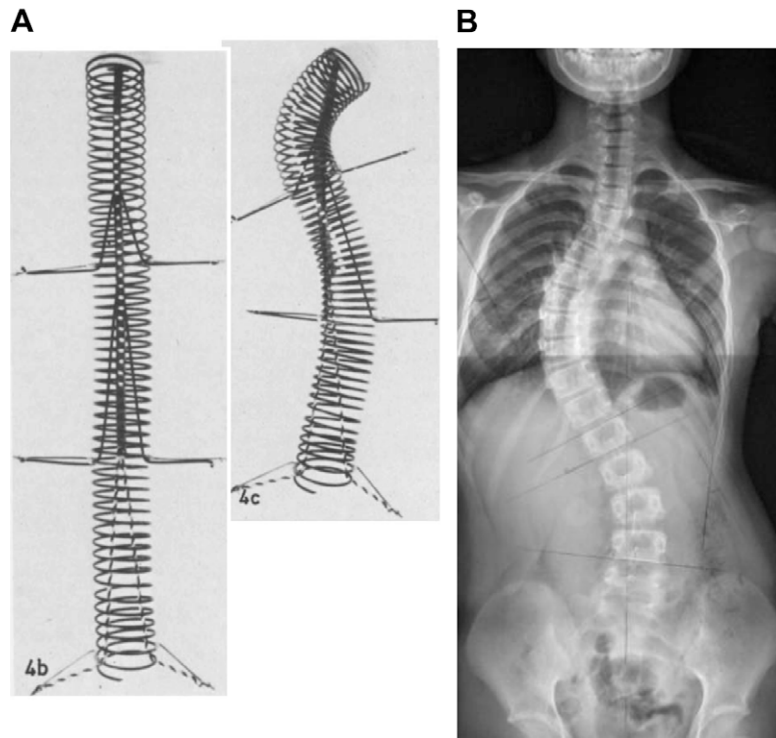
(A) the spring model modified by Roth. (B) Coronal X-ray imaging of an AIS patient.
